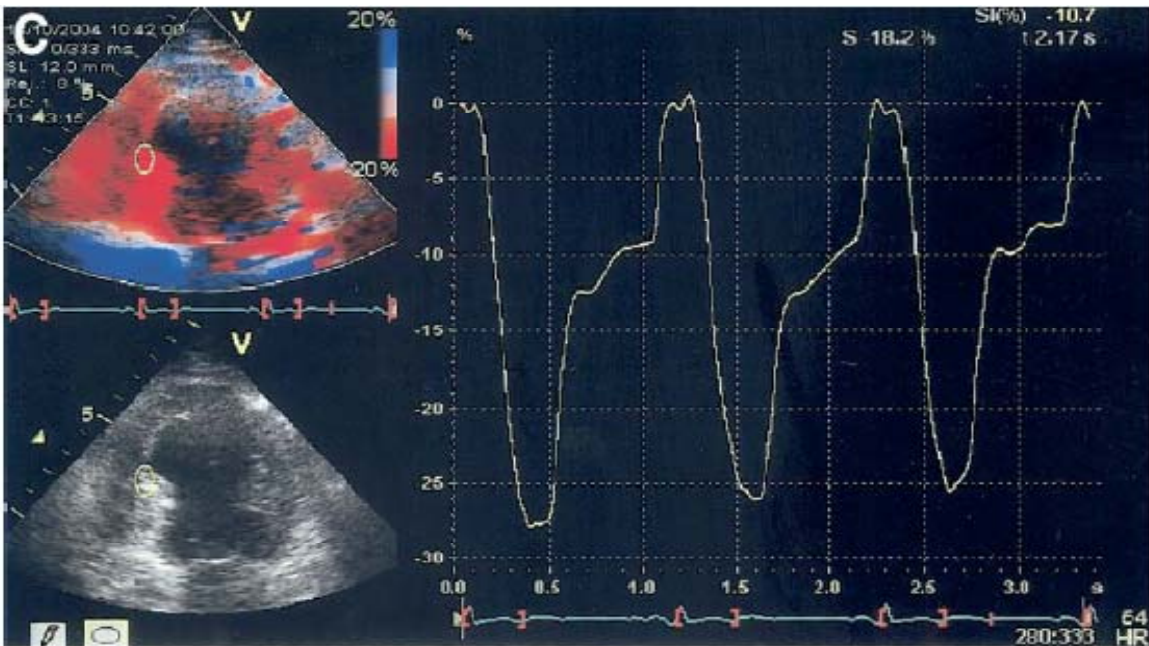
Derivation of strain from tissue Doppler data. Regression calculation between adjacent tissue velocity data points along this length generates the strain rate curve, which is then integrated to calculate strain.
